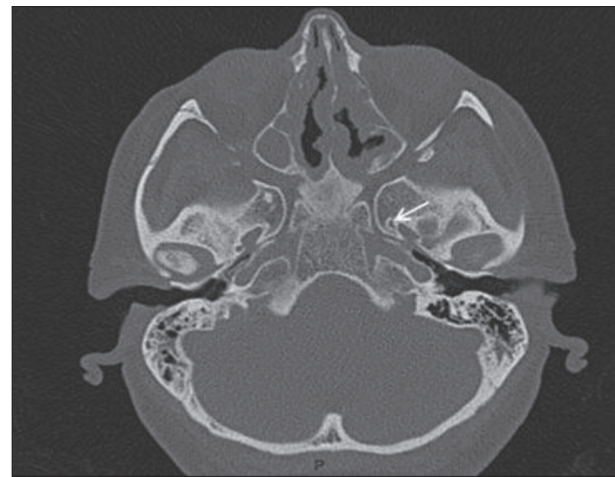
Unilateral foramen (white arrow) on a computed tomography scan
